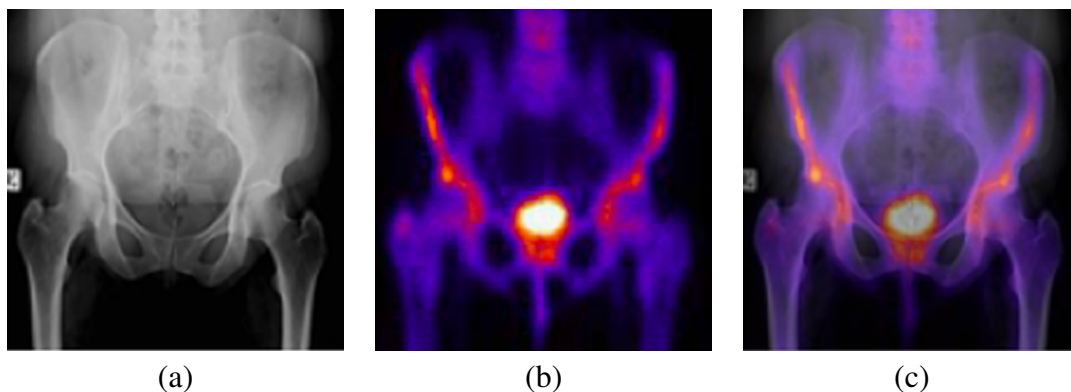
An example of image fusion of hip scans: (a) X-ray image, (b) bone lesion, (c) fused image.
